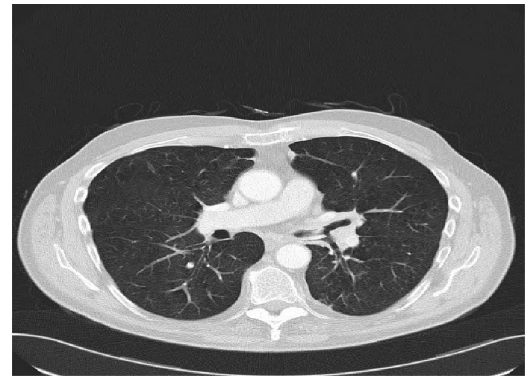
CT thorax: early emphysematous change with consolidation in the left lung and air bronchograms; however, a mass lesion could not be excluded.
